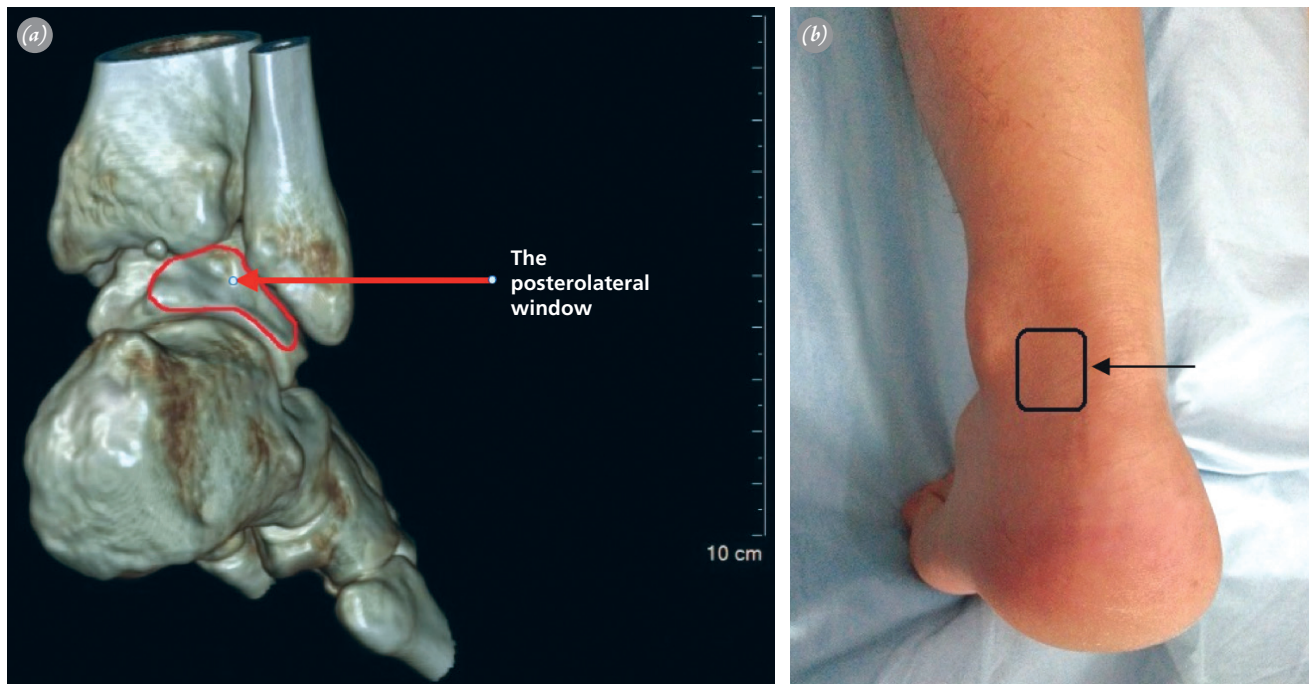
(a) CT scan picture of posterolateral window. (b) The outside view of posterolateral window. [Color figures can be viewed in the online issue, which is available at www.aott.org.tr]
